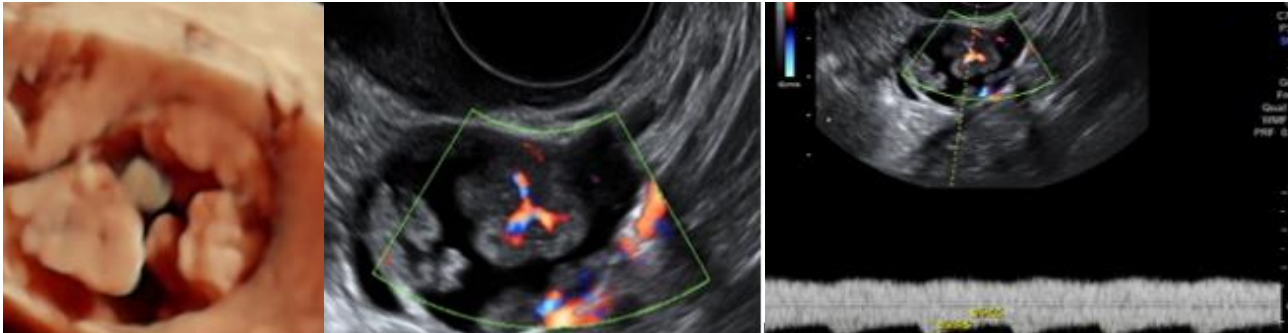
A case of young women 28 years old, primipara; 2D/3D and color Doppler ultrasound: Unilocular-solid appearance of the cyst; >4 papilla; color score 3; central vascularization of papilla RI <0,40 (a-c). Ph: Cystadenoma border line ovarian malignancy.
